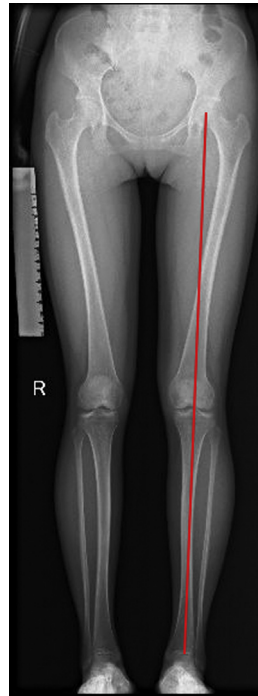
A standard standing long-leg anteroposterior radiograph to evaluate the coronal malalignment of the left leg (the line from the center of the femoral head to the center of the ankle).
